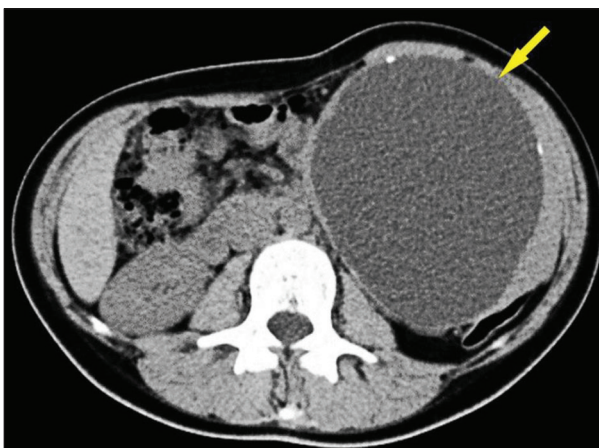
Preoperative abdominal computed tomography finding
